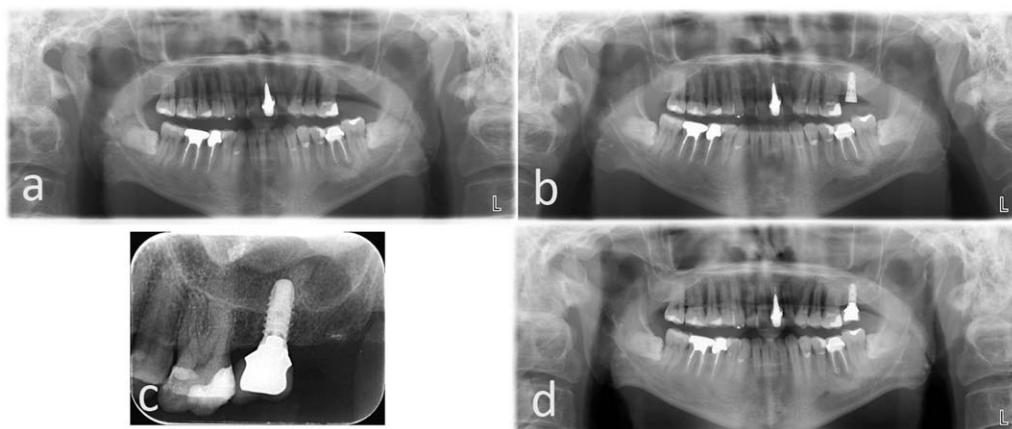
Radiographs after long implant placement. A, Preoperative radiograph; B, Radiograph obtained immediately after long implant placement with lateral sinus elevation. Note the radiopacity around implant; C, Prosthetic load radiograph; D, Radiograph obtained at 2 years. Note the stability of the bone levels.
